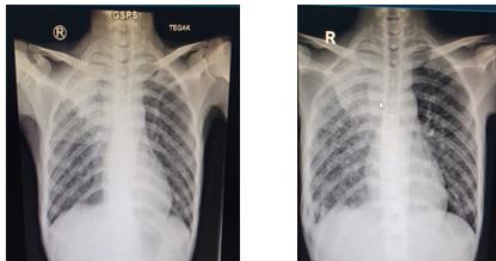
Chest Xray showed Non-Homogen Nodular Opacities.
